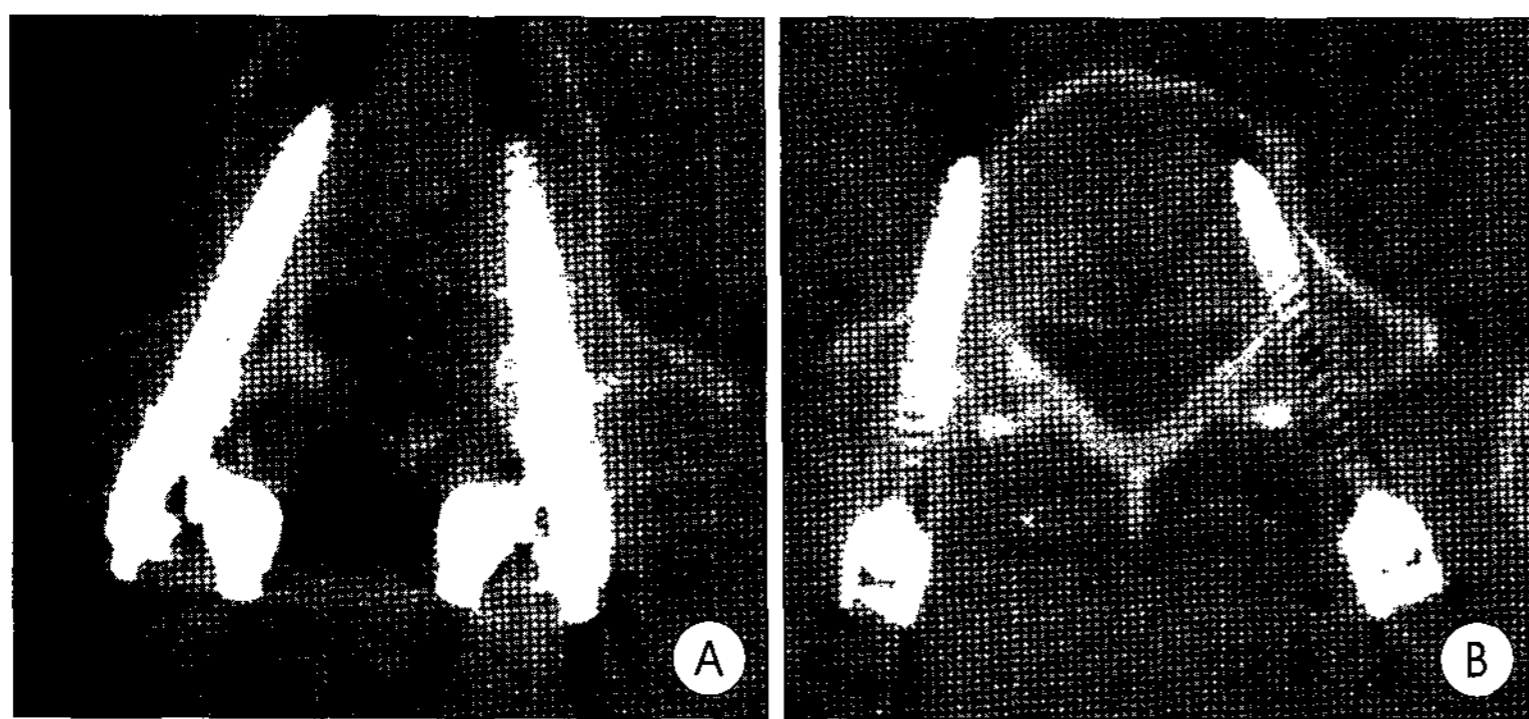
These were the examples of improper placement of screw medial or lateral to the pedicle. A : left screw is medially deviated on computed tomography scan, while right side screw is laterally placed. B : Lateral and extra-pedicle placement of screw with pedicle violation is detected on right sided pedicle.
